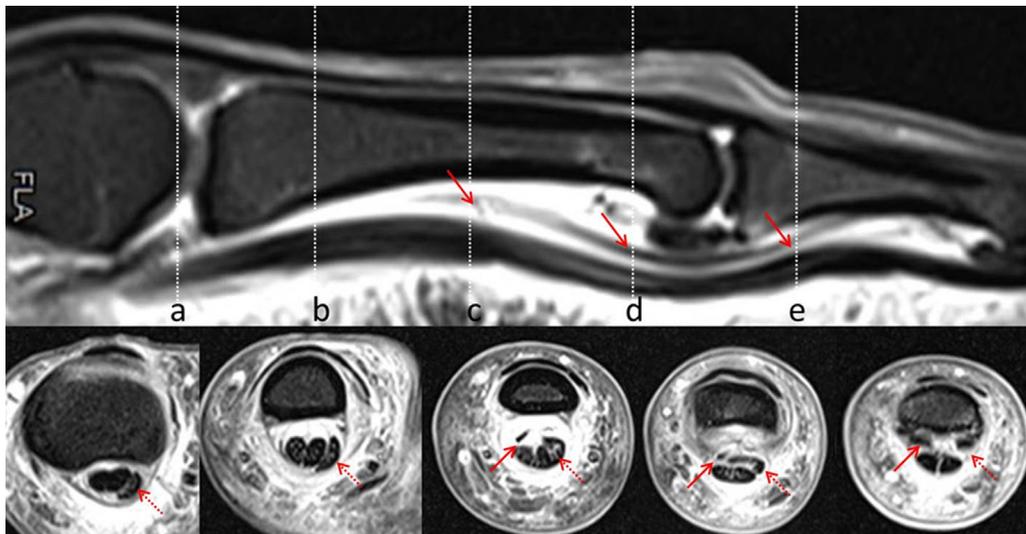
T1-weighted fat-saturated MRI cross sections after intravenous contrast agent injection with five axial images (a–e) and one sagittal image. MRI shows disruption of the radial FDS slip visible at level of the A3 and A2 pulleys (continuous arrows: axial images c, d, e and sagittal image). The undamaged ulnar FDS portion was misaligned inside the tendon sheath with relocation in an ulnar direction at level of the proximal phalanx (all axial images, dotted arrows).
